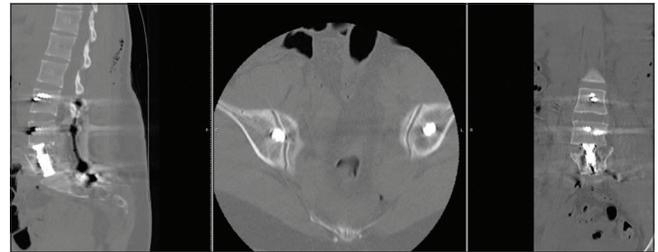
The postoperative computed tomography scan showing the anterior cage with L3-pelvis instrumentation.
